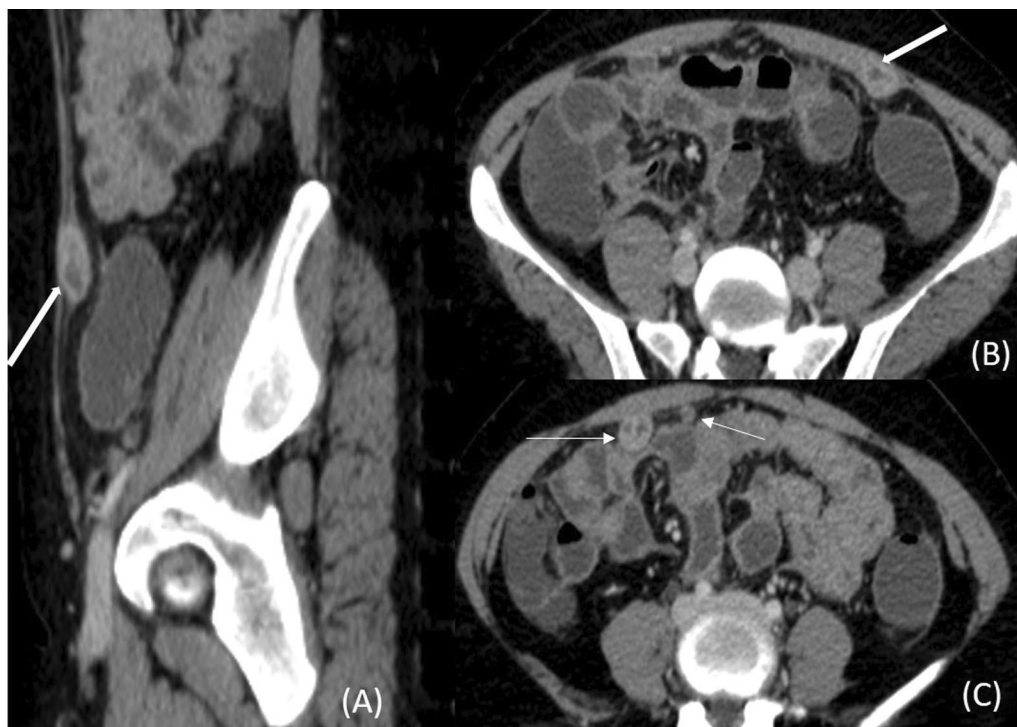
Abdominal tuberculosis with abdominal wall deposits. CT images of a 28-year-old female show a well-defined peripherally enhancing nodular lesion in left rectus abdominis muscle (solid white arrow in A and B) with similar morphology lesions in omentum (thin white arrows in C)
